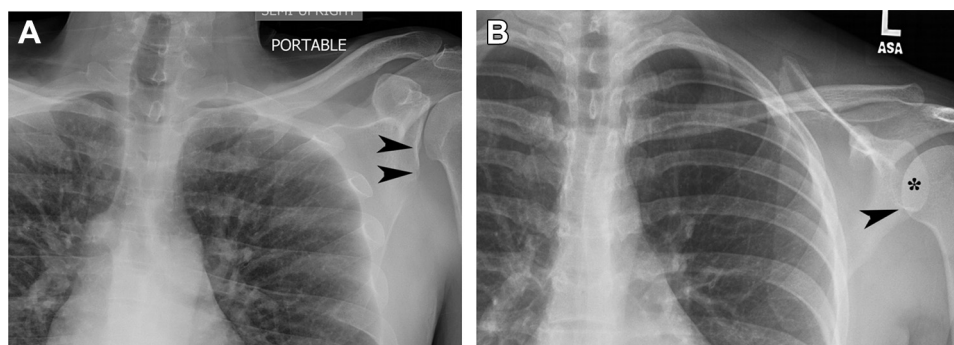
Glenoid retroversion and normal version demonstrated on chest radiographs. (A) Coned down frontal view chest radiograph in this patient demonstrates the hypoplastic left glenoid (arrows) and visualization of the glenohumeral joint in profile. The glenoid and humeral head should normally overlap on a chest radiograph since the glenohumeral joint is obliquely oriented to the X-ray beam. (B) Coned down image from a 22-year-old woman shows the normally formed glenoid (arrowhead) and the normal overlapping (asterisk) of the glenoid and humeral head.
